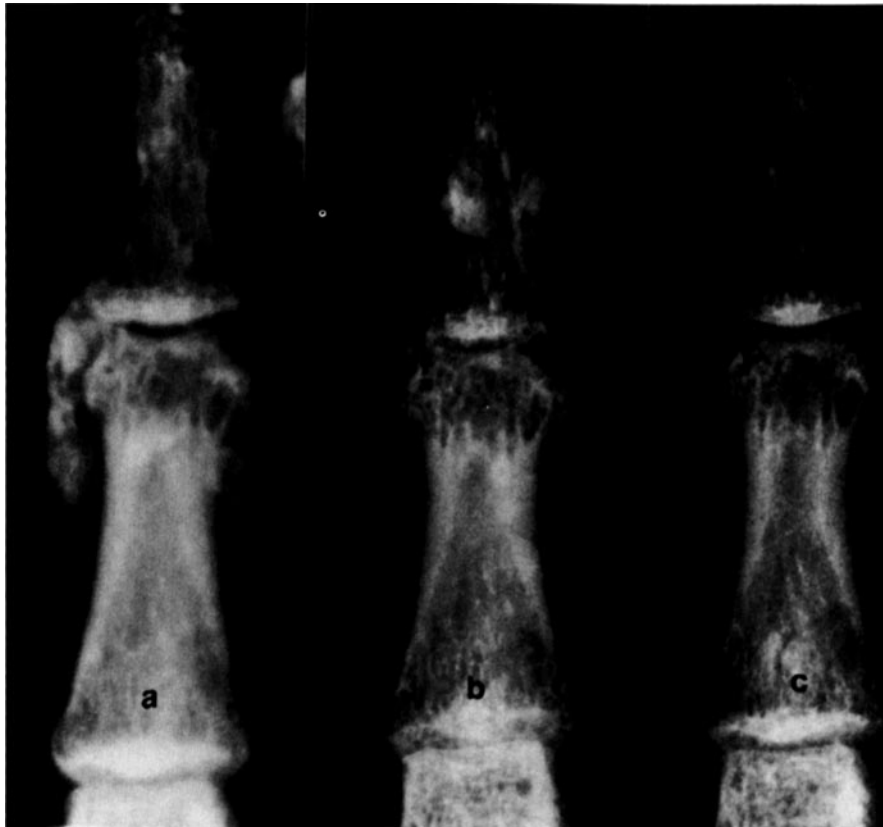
Posteroanterior radiographic views of the patient's right fourth finger. a, In 1983, there were extensive periarticular calcifications surrounding the distal interphalangeal joint. Note the small amorphous calcifications in the soft tissues adjacent to the distal phalanx and a small erosion of the tip of the phalanx, with punctate calcification. b, In 1984, the amorphous calcification surrounding the distal interphalangeal joint had decreased. c, In 1988, there was almost complete resolution of the periarticular calcifications.
